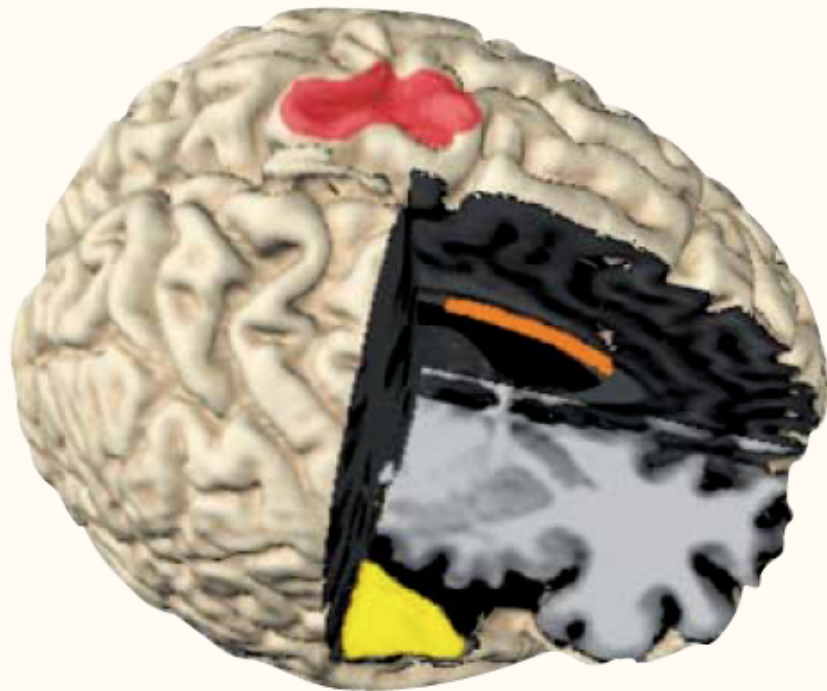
Structural changes in the brains of musicians. Some of the brain areas that have been found to be enlarged in musicians in morphometric studies based on structural magnetic resonance imaging. Red, primary motor cortex; yellow, planum temporale; orange, anterior part of the corpus callosum.
